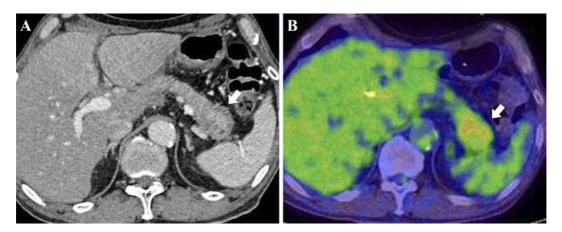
CT and ¹⁸F-FDG PET/CT findings of the remnant pancreatic tail in 2015. (A) CT showed swelling in the remnant pancreatic tail with a capsule-like rim (white arrow). (B) ¹⁸F-FDG PET/CT showed an abnormal accumulation in the swollen remnant pancreatic tail (SUV_{max} 3.9) (white arrow). ¹⁸F-FDG: ¹⁸F-fluorodeoxyglucose, CT: computed tomography, PET: positron emission tomography, SUV_{max}: maximum standardized uptake value
